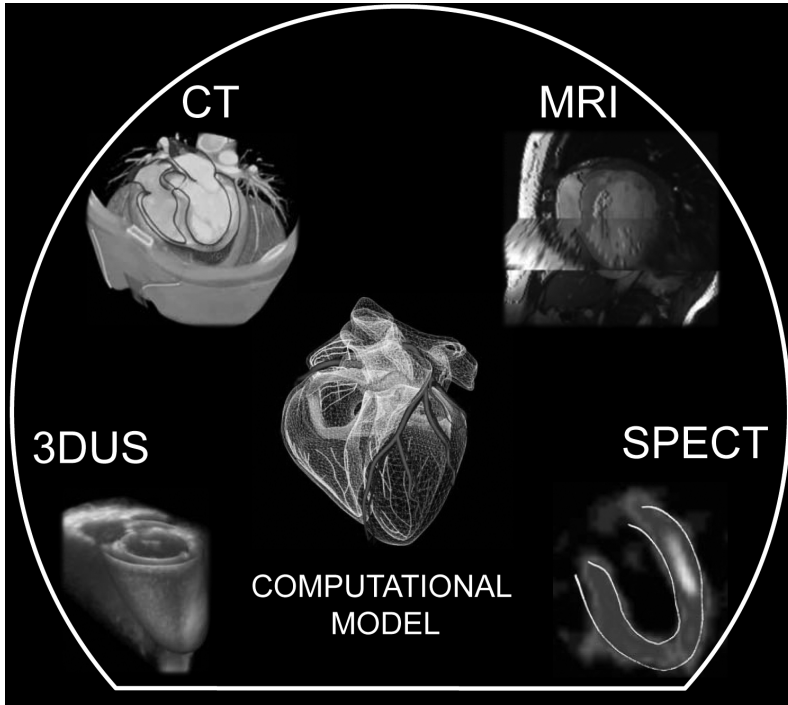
Active Shape Models are a robust and accurate approach to quantify cardiac parameters from multimodal image data. They can evaluate the spatio-temporal variability of the heart. 3DUS= Three-dimensional ultrasound; CT= Computed Tomography; MRI= Magnetic Resonance Imaging; SPECT= Single Photon Emission Computed Tomography. (See color insert)*
